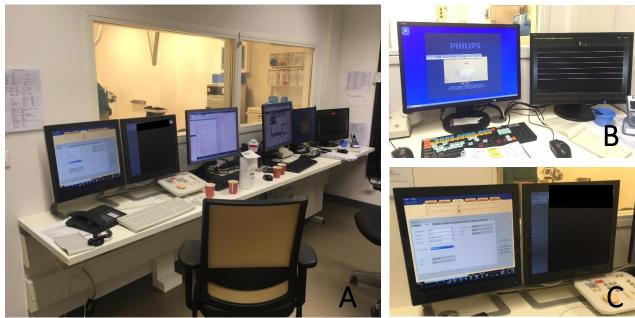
A) Visualisation of the control room of the Cath lab. The first 2 computers on the left run the DoseWise software and save the imaging of the X-ray imaging system(B). The 2 computer on the right are equipped with Xper information system (C)
